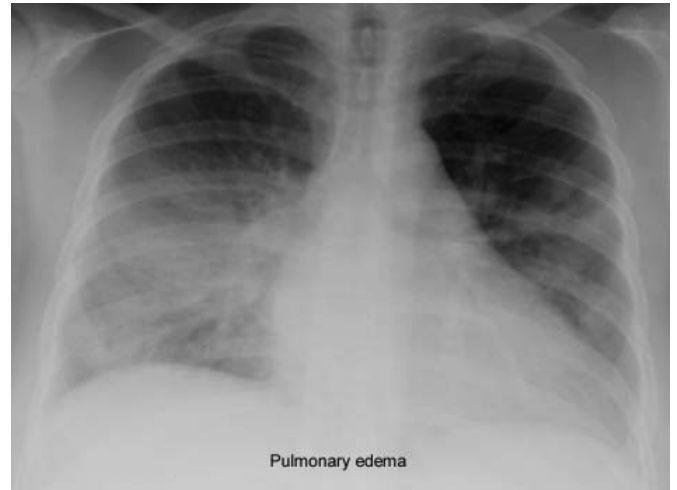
Roentgenogram of the chest of the pregnant woman with SLE complicated by pulmonary edema.
